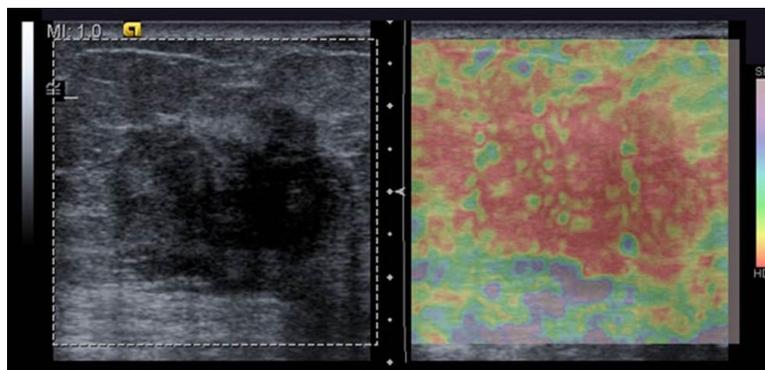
(Left) Echographic image of a biopsy proven breast carcinoma; (Right). The elastogram depicts the deformation caused by the quasi-static compression for each pixel on the image. The lesion appears significantly stiffer (reddish) than its healthy surrounding tissue. eSie TouchTM software elasticity imaging – ACUSON S200 ultrasound system (SIEMENS).
